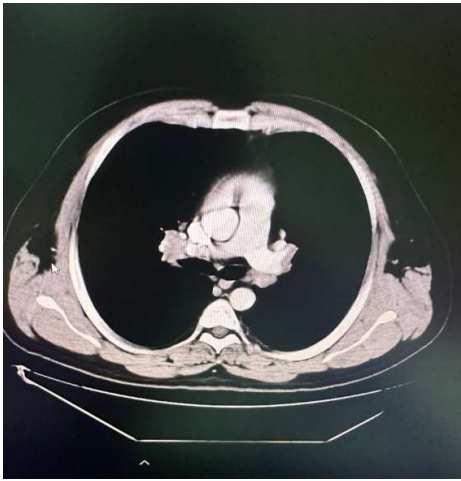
Chest CT with mediastinal window showing hilar lymphadenopathy
